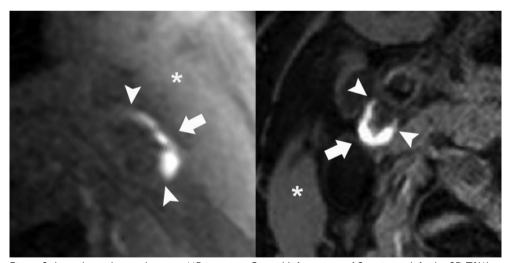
Intraplaque hemorrhage on MR imaging. Carotid bifurcations of 2 patients: left, the 3D-T1W fat suppressed spoiled gradient echo sequence (Discovery MR 750; GE Healthcare), and right, the 2D-T1W inversion recovery turbo field echo sequence (Achieva; Philips Healthcare). In both patients, intraplaque hemorrhage is present (arrows; arrowheads indicate the edges of the intraplaque hemorrhage), defined as a hyperintense signal in the atherosclerotic plaque compared with the sternocleidomastoid muscle (asterisk).
